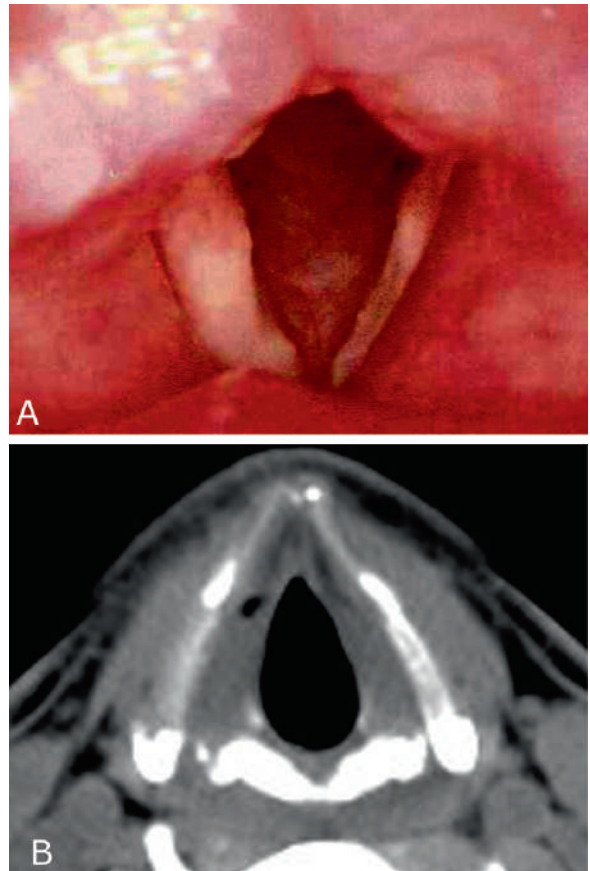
Bronchoscopic image (a) correlated with axial CT image (b) of the vocal cords of the same patient shows thickening of both vocal cords, with the right one markedly thickened compared to the left one in (a). In (b), the CT image shows hypodense areas found in the anterior aspect of both vocal cords bilaterally involving the anterior commissure (arrowheads), with subtle left vocal cord thickening anteriorly
